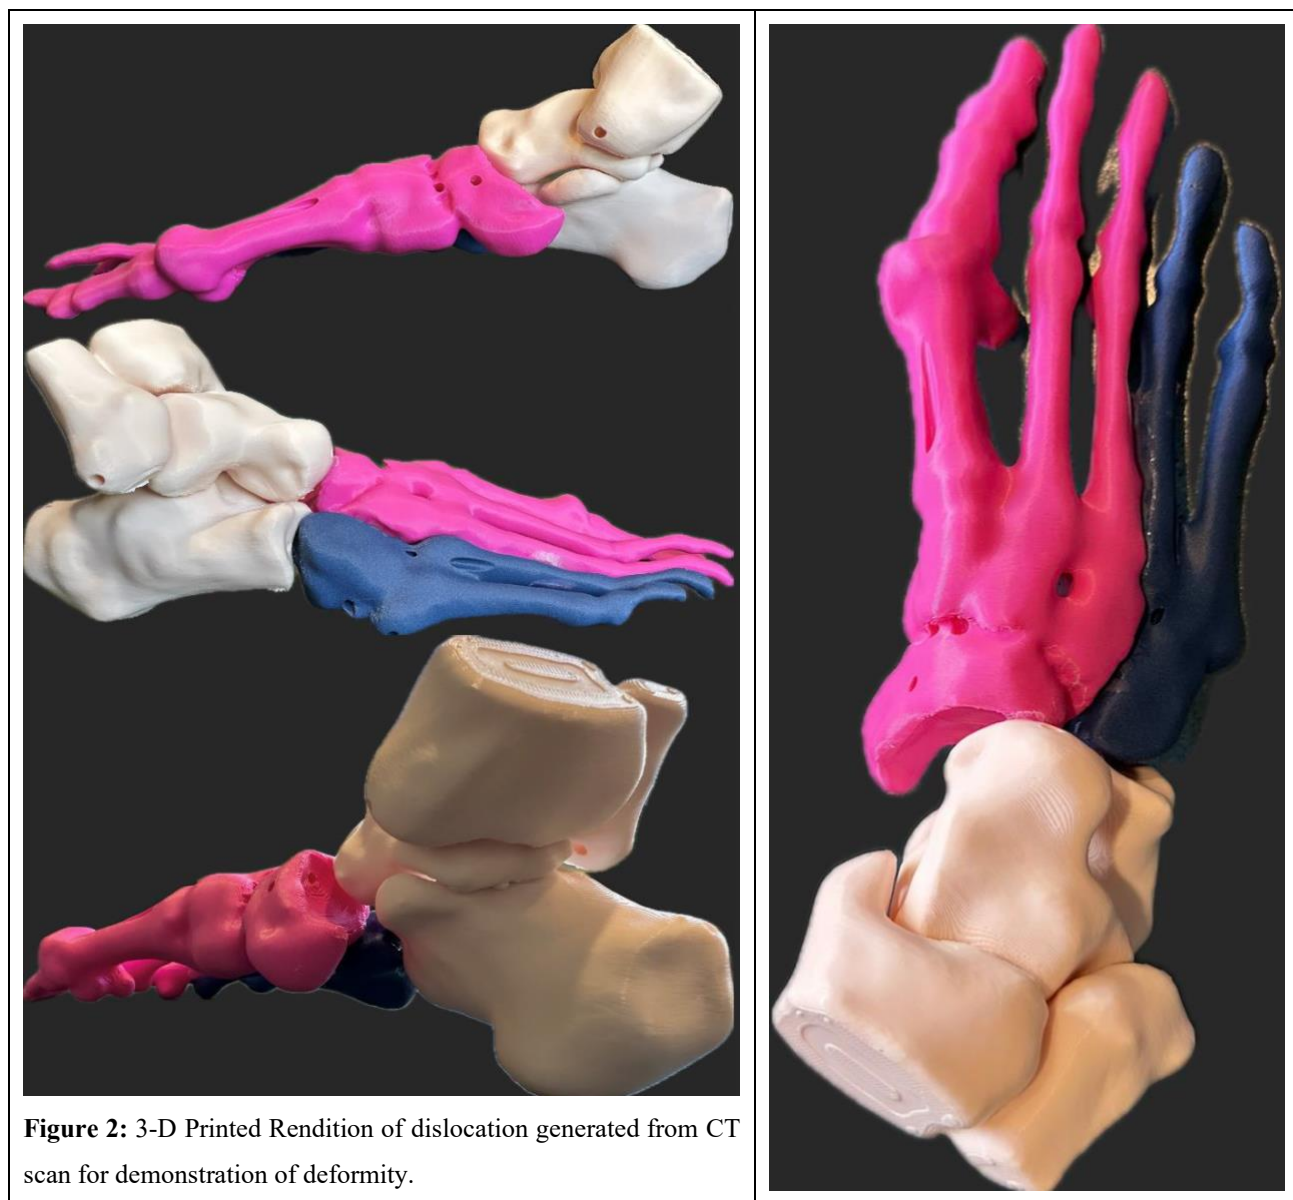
3-D Printed Rendition of dislocation generated from CT scan for demonstration of deformity.
